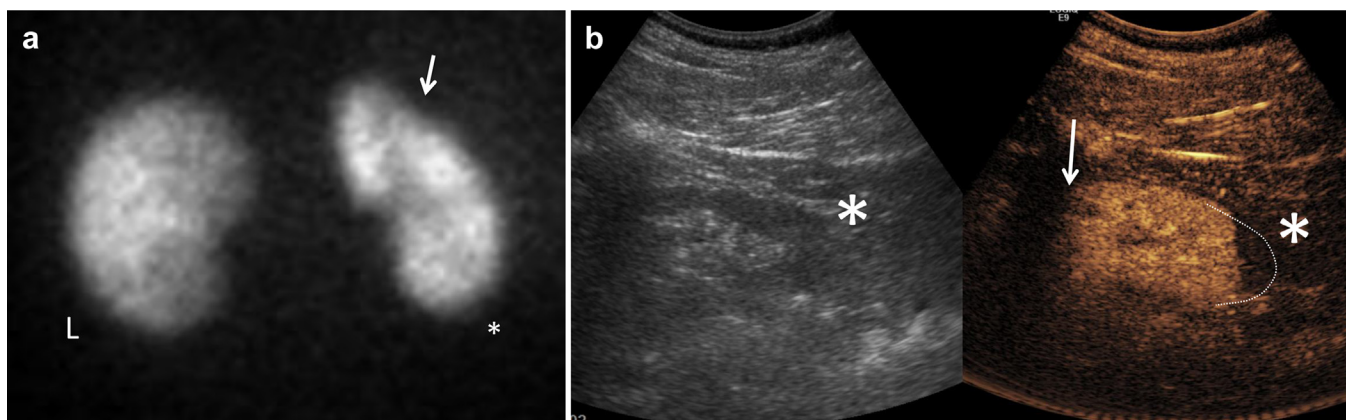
(a) ^{99m}Tc -dimercaptosuccinic acid (DMSA) scan of subject (patient CEUS-003) with normal size and shape of left kidney (L). The right kidney has a wedge-shaped filling defect in the upper pole (arrow). Lower pole of right kidney has subtle blunting of renal contour (*). (b) (Left) grayscale conventional ultrasound image with normal corticomedullary differentiation and lower pole contour of right kidney (*). (Right) large area of hypoechoic enhancement of lower pole (*) highlighted by dashed line. Arrow corresponds to wedge-shaped defect demonstrated in (a) (arrow) DMSA scan.
